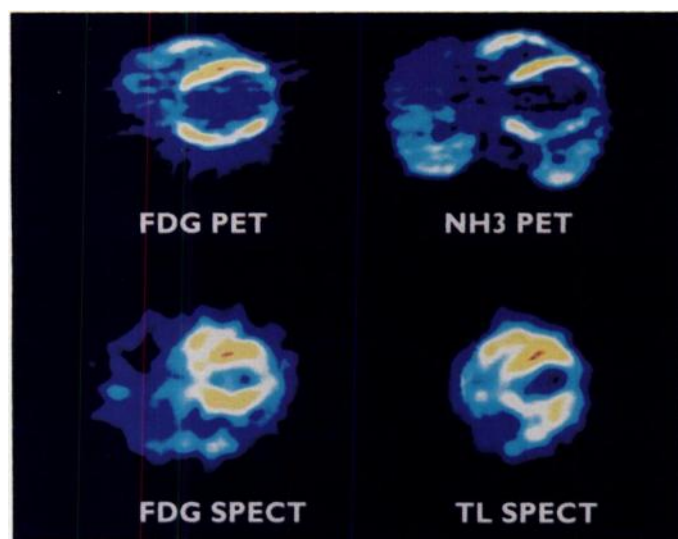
Corresponding transaxial slices of a patient with a matching defect in the anteroapical region (decreased perfusion and decreased FDG uptake) and a mismatch in the infero-lateral region (decreased perfusion with preserved FDG uptake). Although the resolution of the SPECT images is inferior to the PET images, the clinical relevant information can be derived from both studies.
